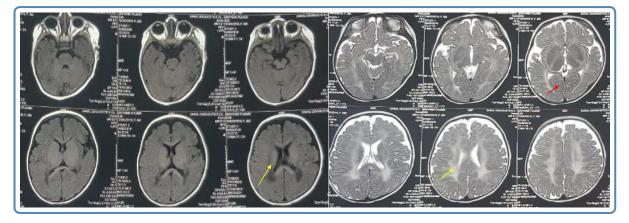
MRI Brain: T1 and T2 weighted images showing diffuse involvement of both deep and subcortical white matter of cerebrum (yellow arrows) and cerebellum (red arrows) suggestive of hypomyelination.
